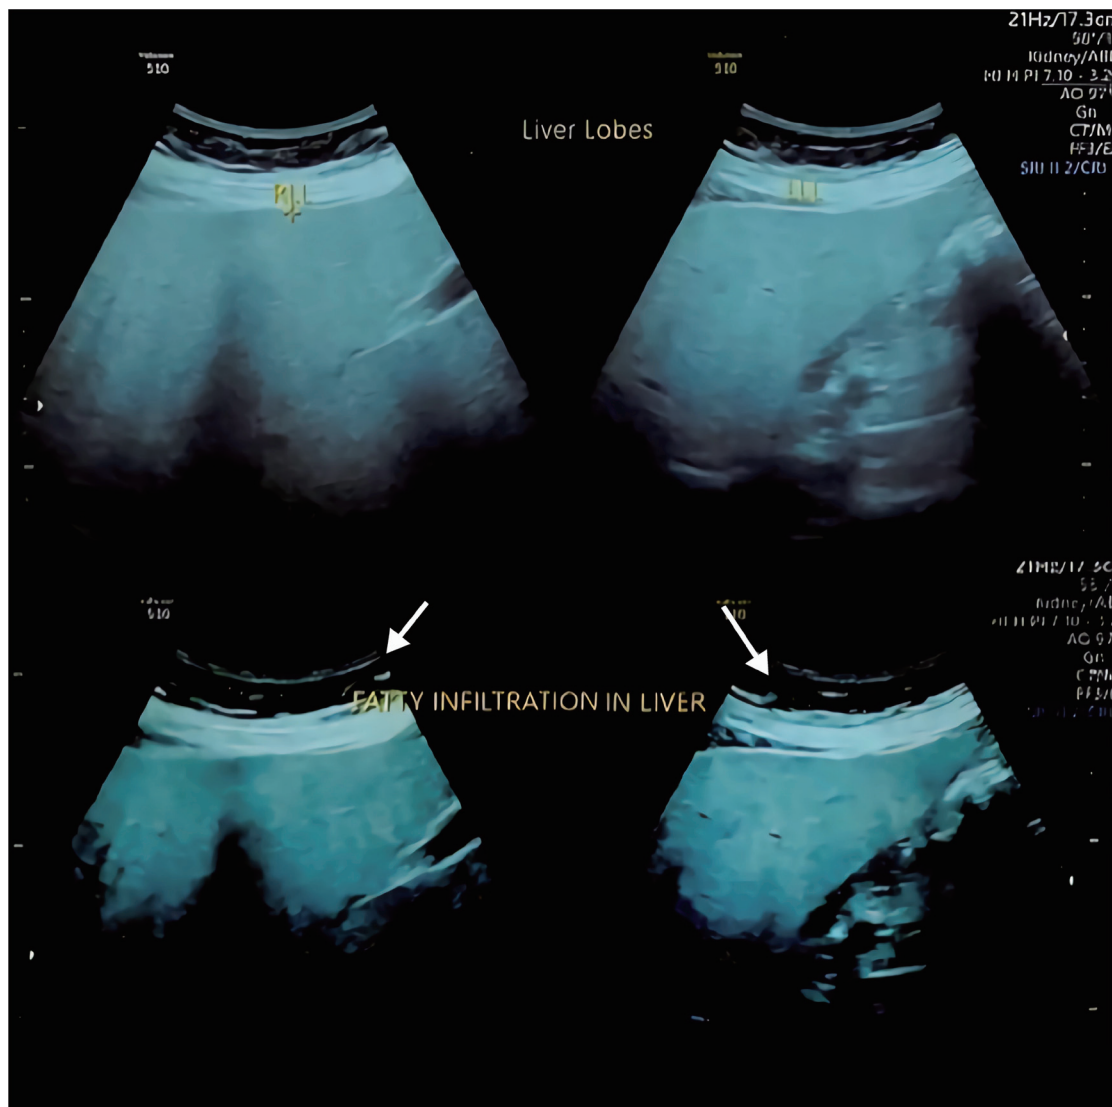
Ultrasound showing fatty infiltration in the liver. The arrows show increased echoes signifying fatty changes in the liver.
